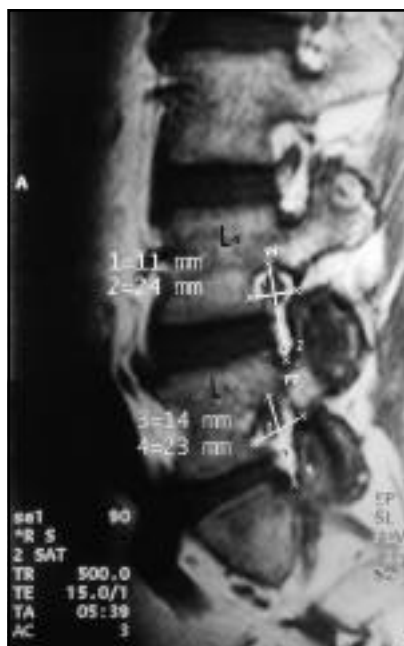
Sagittal MR image of the lumbar spine, demonstrates positions of markers for measuring the foramina heights (FH) between L4/L5.
